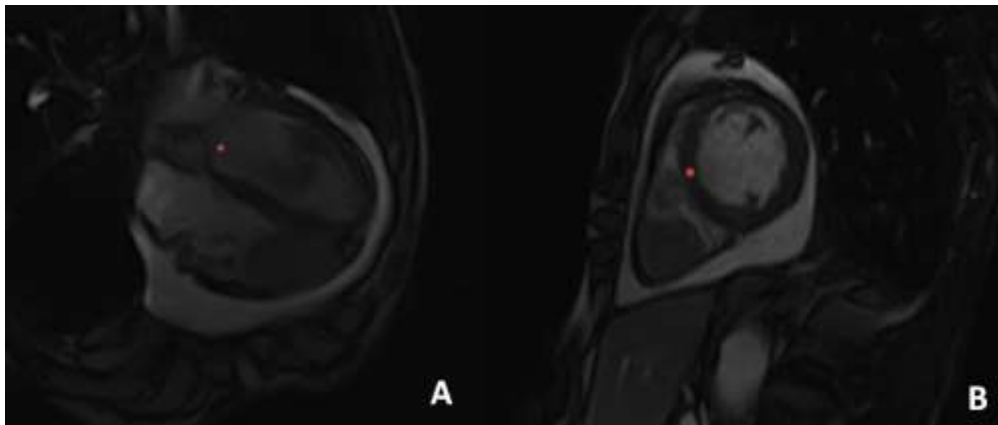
cardiac MRI confirmed the presence of a large tumor mass measuring 56 x 39 mm, filling two-thirds of the apical region of the right ventricle.
